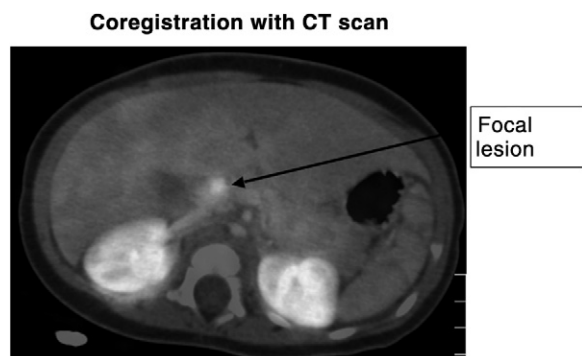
Positron emission tomography scan is coregistered with a computed tomography scan that shows a focal lesion (arrow) in the head of the pancreas. The kidneys excrete the 18-FluoroDOPA and also light up.
